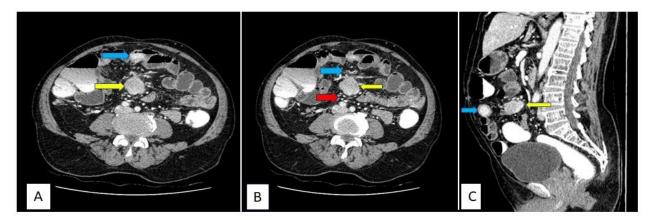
A 75-year-old male – known case of DM presented with lower abdominal pain and constipation. CECT Abdomen was done. A) Axial CT show well-defined moderately enhancing soft tissue mass (yellow arrow) within the small bowel mesentery in an infra umbilical paramedian location. Adjacent small bowel loop, anterior to the lesion shows enhancing eccentric focal wall thickening (blue arrow). B) Axial CT show moderately enhancing soft tissue mass (yellow arrow) within the small bowel mesentery, associated neovascularization (blue arrow), and few sub-centimetric lymph nodes adjacent to it (red arrow). C) Sagittal CT show moderately enhancing soft tissue mass within the small bowel mesentery in the infra umbilical paramedian location (yellow arrow) and enhancing eccentric focal wall thickening in the adjacent small bowel loop anterior to the lesion (blue arrow). HPE demonstrated features of NET involving the ileum
